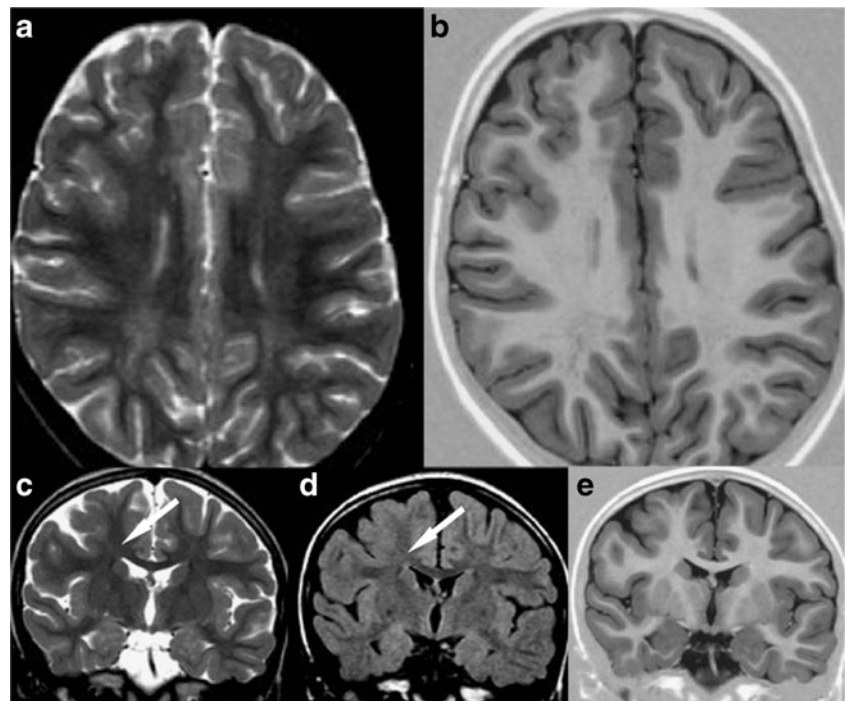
FCD IIa: a axial TSE-T2WI, b axial IR-T1WI, c, d, e coronal TSE-T2WI, FLAIR-T2WI, and IR-T1WI. A gyration anomaly is seen in the right frontal region characterized by dysmorphic and deep sulci which are surrounded by thickened cortex. The GM/WM junction is blurred in all pulse sequences. Only mild hypersignal of the subcortical WM is seen, extending deeply, without a “funnel-shaped” appearance
